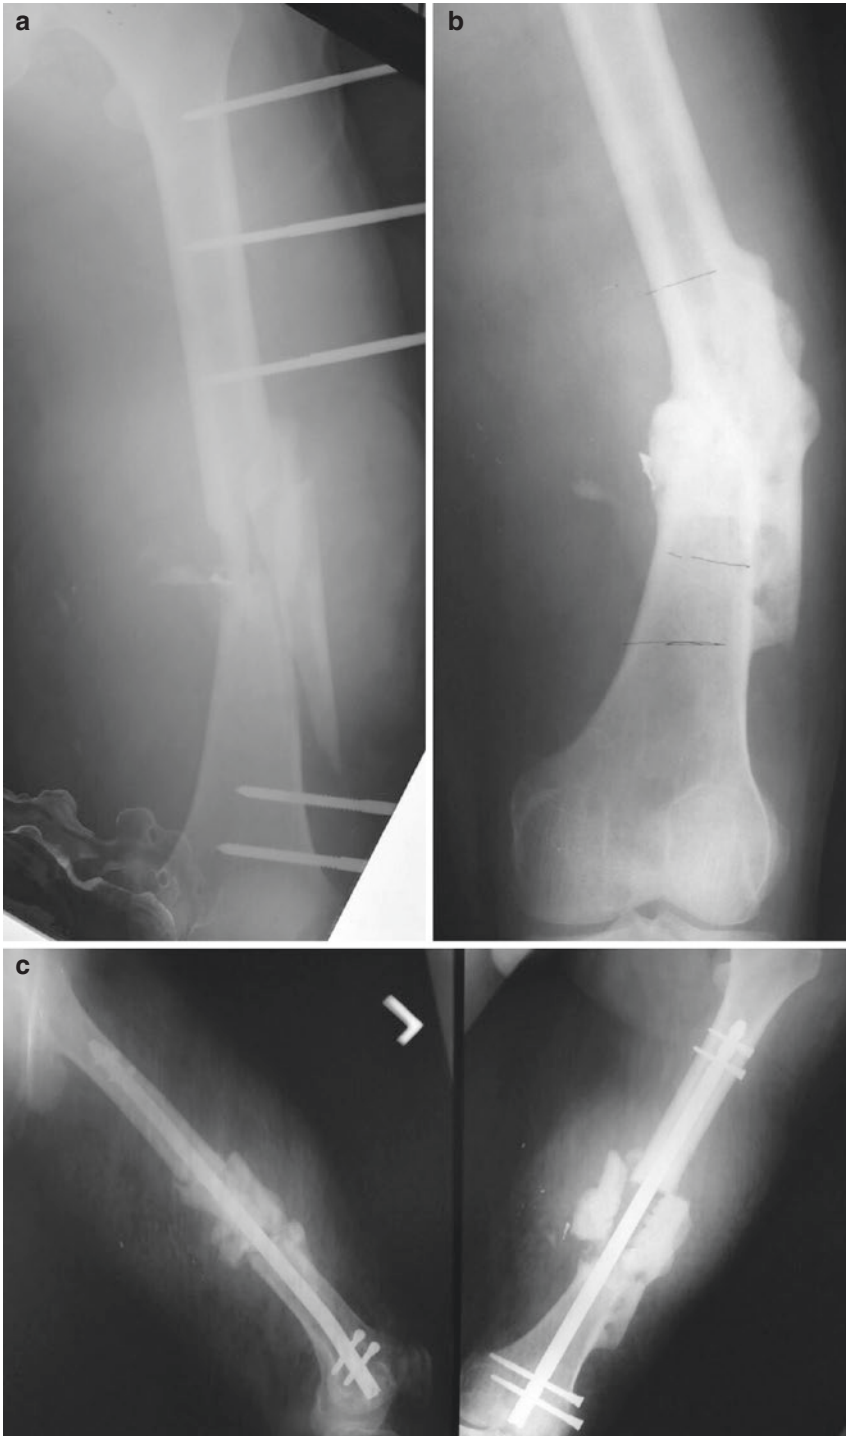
(a) This 45-year-old male's IIIA open femur fracture from a gunshot was debrided and placed in an ex fix in 10° varus. (b) After removal of the ex fix and unprotected weight-bearing, the varus increased to 20°. (c) X-ray after clamshell osteotomy secured with a locked retrograde nail. No extra bone graft was used. (d) AP and lateral X-rays taken 2 years after the osteotomy show and patient's femur healed without deformity or shortening, and he walks with a normal gait and full squat
